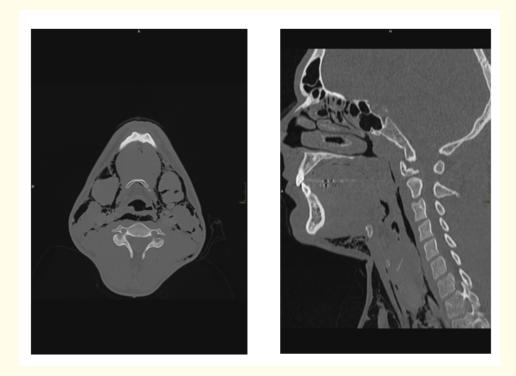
Axial and sagittal CT neck MPRs shows gas involving both the retropharyngeal and danger space.
